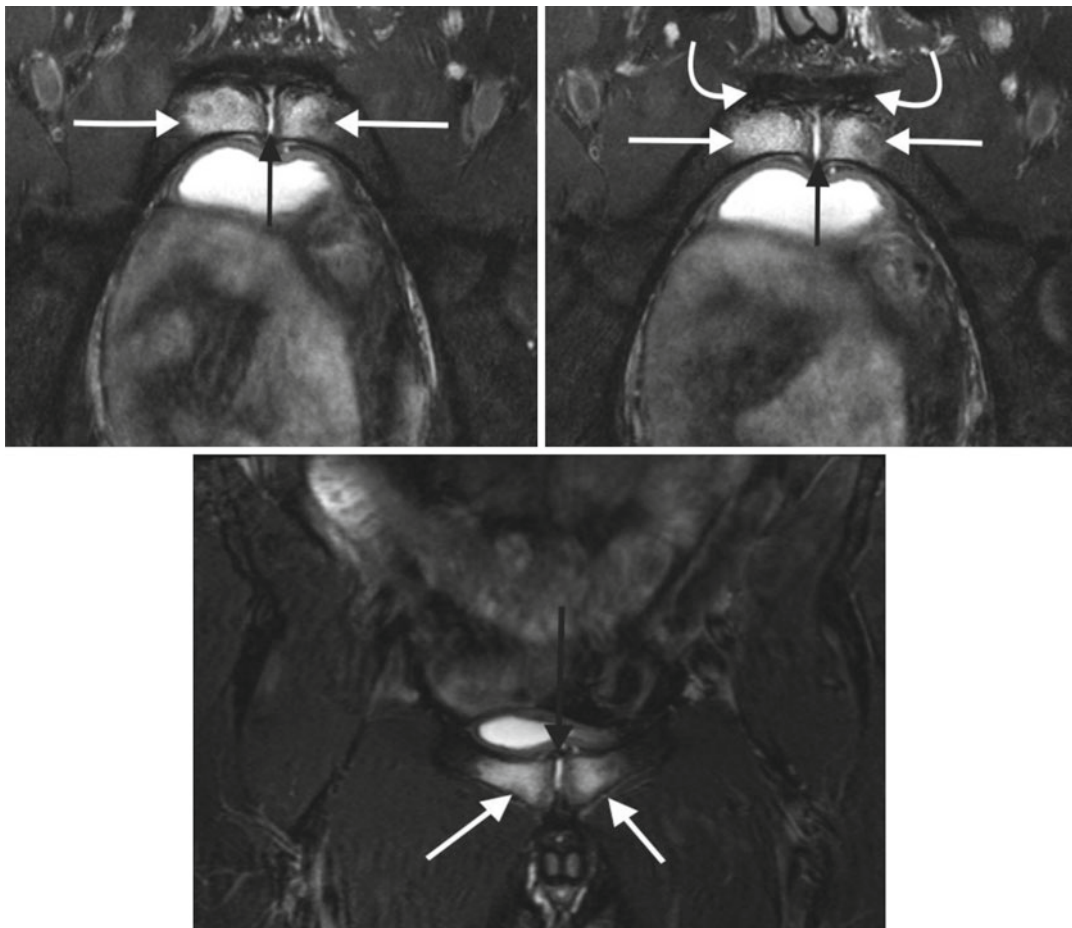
(Top left, top right) Moderate bone marrow edema spanning the subchondral region of the pubic symphysis anterior to posterior on an axial fat-saturated T2-weighted image (*white arrows*) typical for severe osteitis pubis. There is fluid in the pubic symphyseal cleft
